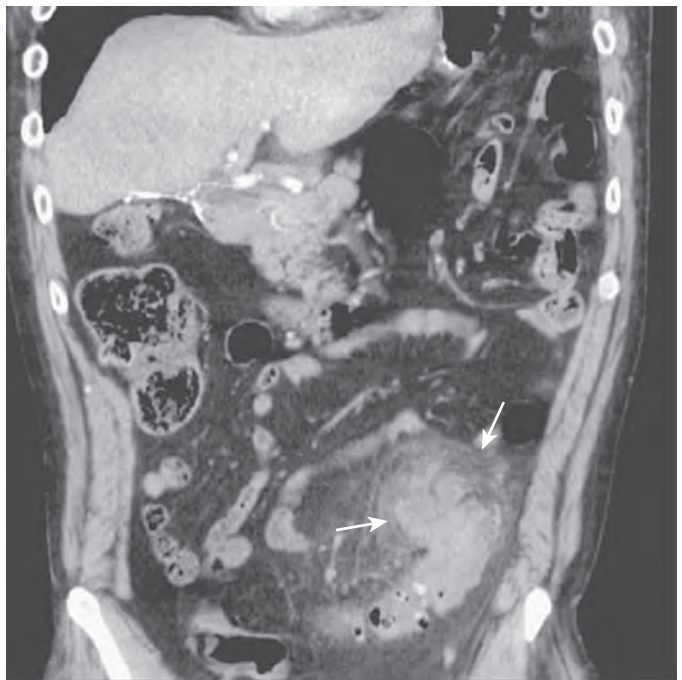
Diverticulitis of the sigmoid colon: CT findings. Coronal reformatted image shows mural thickening of the junction of the sigmoid and descending colon and a phlegmon (arrows) in the sigmoid mesocolon.
